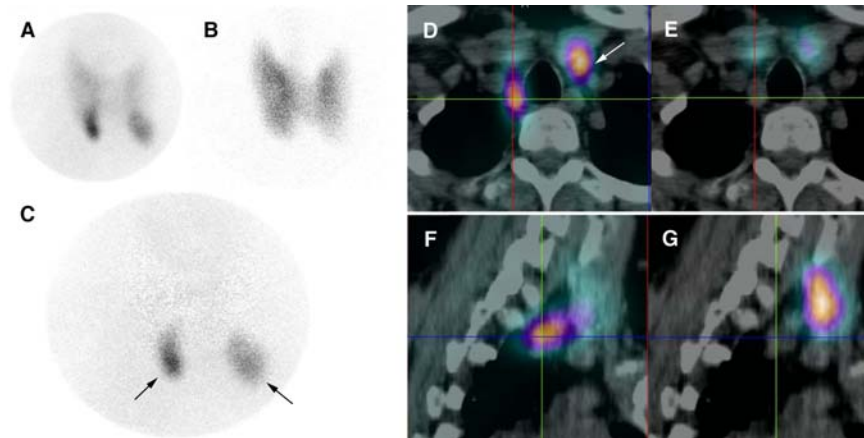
Patient with PHPT and previous history of subtotal thyroidectomy for Graves' disease. Neck ultrasound examination suggested a parathyroid lesion on the lower right side. Simultaneous dual-tracer acquisition of ^{99m}Tc -MIBI and ^{123}I was performed after thyroid hormone replacement therapy was withheld for two weeks.
